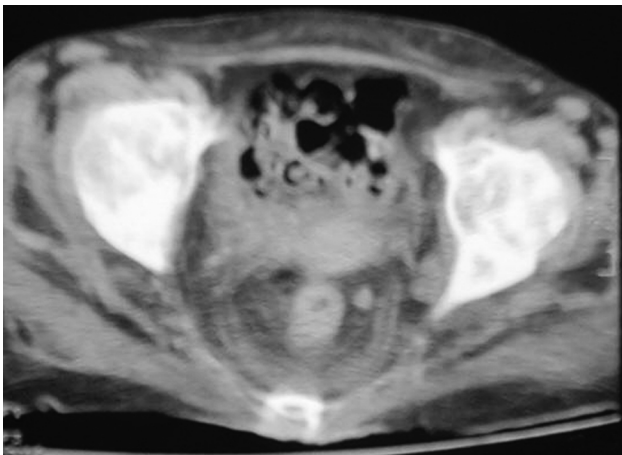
a) Axial CT section at the level of acetabulum showed asymmetric wall thickness resembling tumoral mass at right side of rectum. Focal increased density resembling osteoblastic metastasis of acetabulum and proximal femur was also seen
